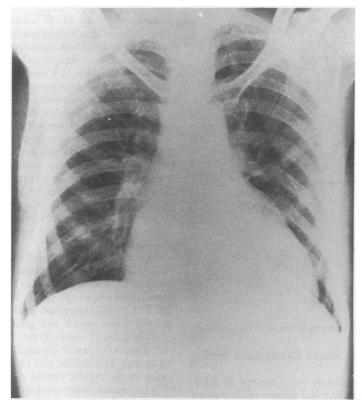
X-rays: (frontal view): mitral configuration. Left atrial and auricular appendage enlargement. Pulmonary venous hypertension.
